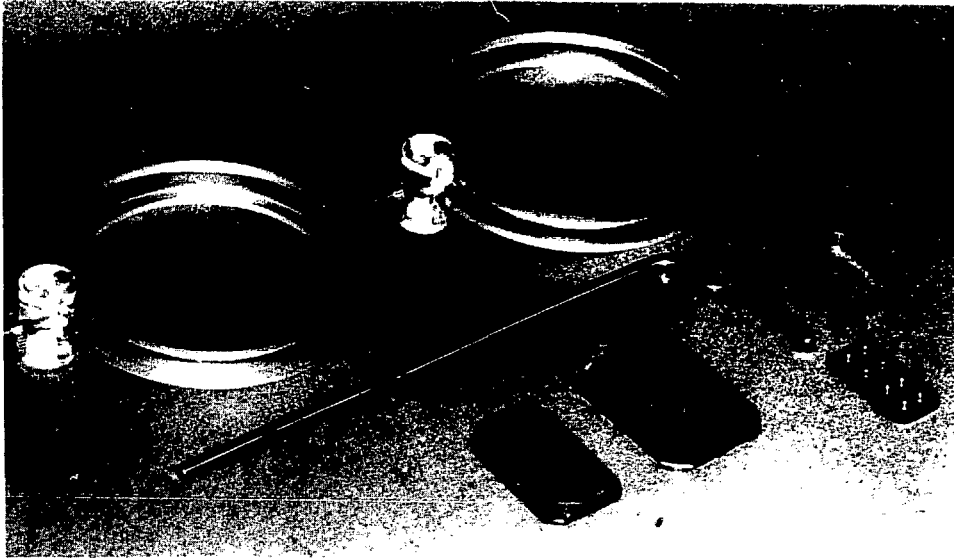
Aiming device for making reproducible intraoral bite-wing radiographs. The disassembled device consists of an indicator rod, two locator rings of synthetic material, an aluminium bite-block, a film holder for format 2 films and a film holder for format 1 films.
